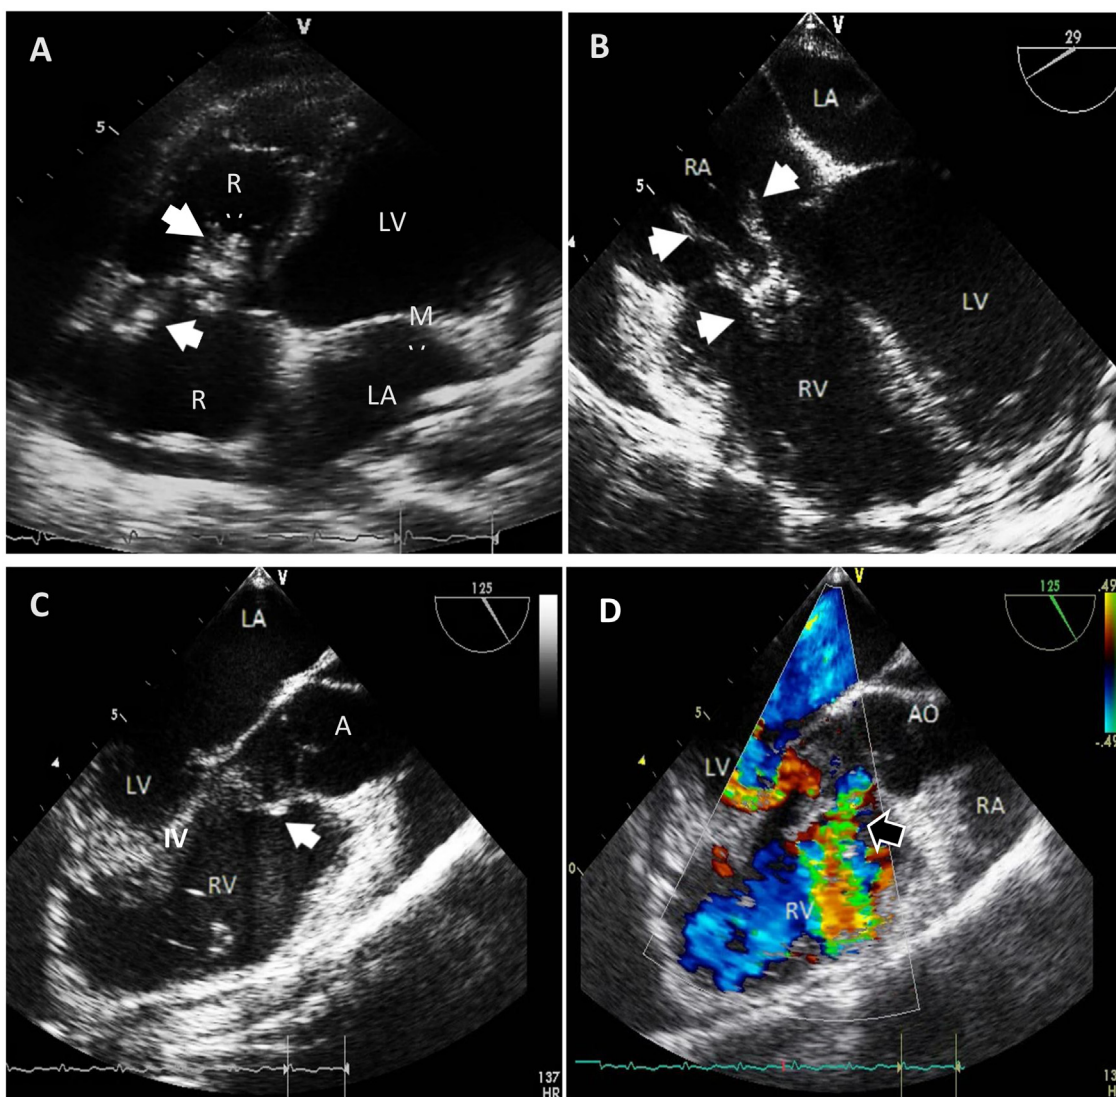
Images A & B images demonstrate destroyed & flailing tricuspid valve (TV), in addition to attached & mobile vegetations in different sizes (white arrow heads). Image C demonstrates a small size vegetation attached to the right side of VSD (black arrow head with white margins). A. Transthoracic (TTE) apical four chamber off-axis view. B. Transeophageal (TEE) four chamber view (mid esophageal). C. TTE four chamber view (modified mid esophageal). D. Color Doppler TEE (in the same view as shown in image C). Abbreviations: AO: aorta. IVS: interventricular septum, LA: left atrium, LV: left ventricle, MV: mitral valve, RA: right atrium, RV: right ventricle.
